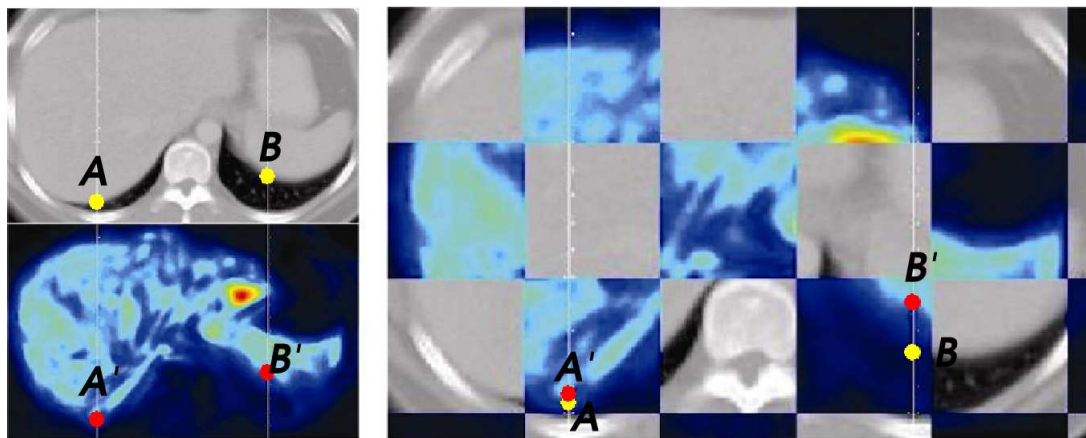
Evaluation example using the proposed visual assessment protocol in an abdominal case. Left: 2D axial slices of the original CT (top) and the registered emission PET (bottom) images. The registration accuracy is evaluated in the liver (A-A') and the stomach (B-B') using the landmark points (yellow in the CT and red in the emission PET slices) and the ruler. Right: chessboard image with landmark points from each image modality.
